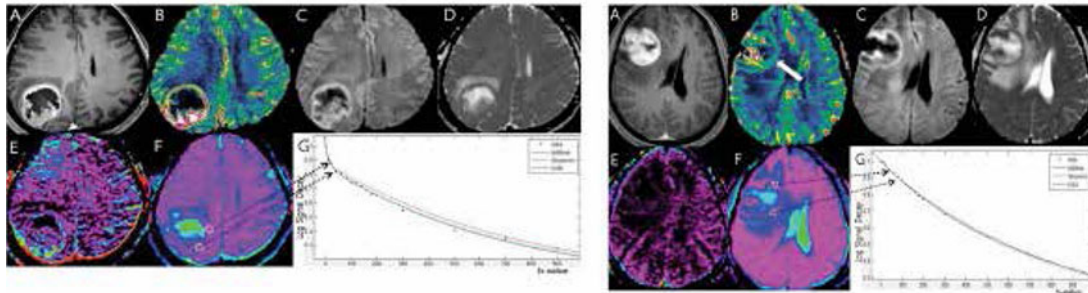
Glioblastoma. A, contrast-enhanced T1-weighted image. B, Normalized CBV. C, DWI.
